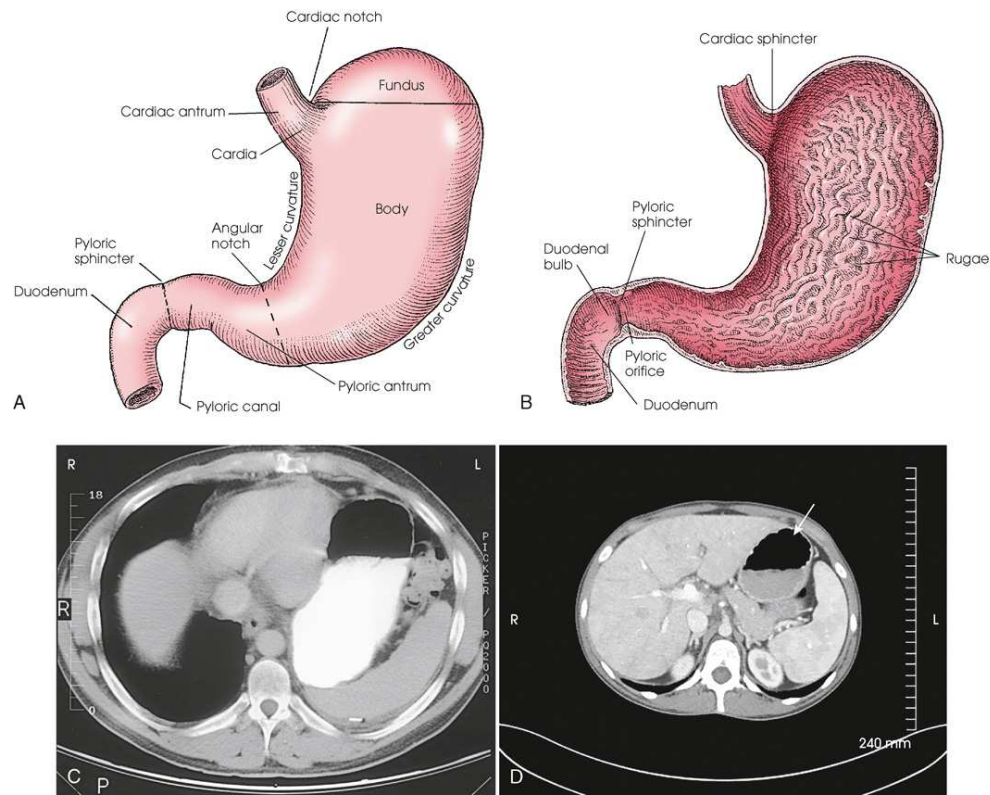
(A) Anterior surface of stomach. (B) Interior view. (C) Axial CT image of upper abdomen showing position of stomach in relation to surrounding organs. Note contrast media (*white*) and air (*black*) in stomach. (D) Axial CT image showing stomach without contrast media. Note air (*arrow*) and empty stomach. D, Courtesy Heath Yarbrough, RT[R][MR][CT], NEA Baptist Memorial Hospital, Jonesboro, AR.
